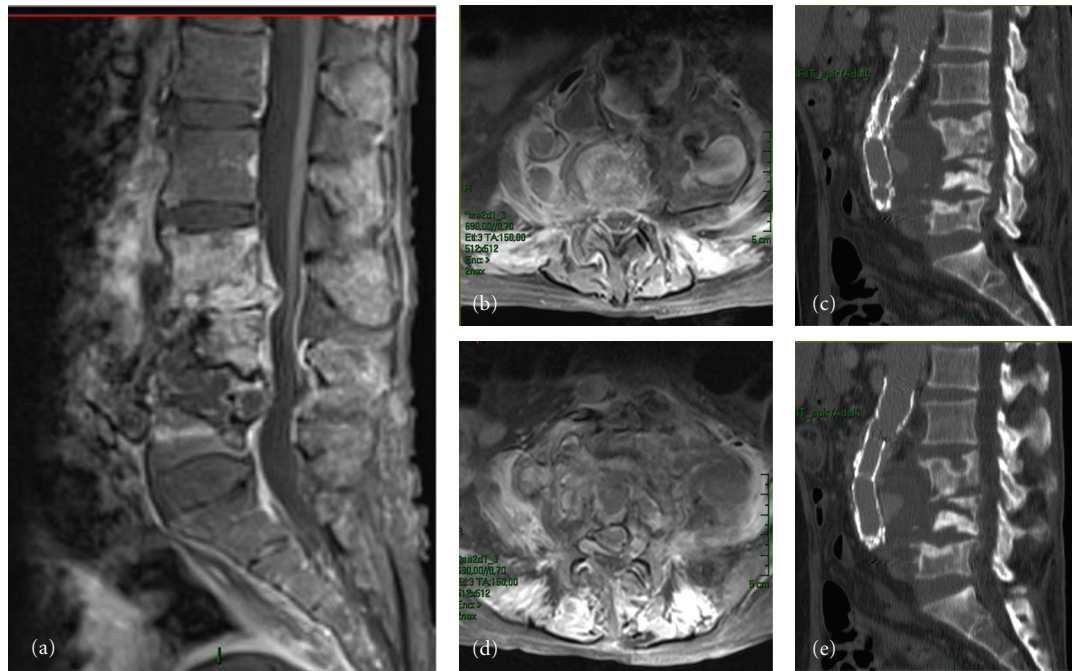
(a) Sagittal MRI, T1 showing the extension of the infectious process to three vertebral bodies L3-L4-L5 and to the intervertebral discs, as in a case of spondylodiscitis. ((b) and (d)) Axial MRI, T2 showing the paravertebral extension of the infection as well as an important compression of the sack and roots by the infection. ((c) and (d)) Sagittal CT showing the erosion and an extended rehaching of the bone as well as the involvement of the aortic prosthesis which has in part been pushed forwards by the infection. The CT also shows the integrity of the vertebral plain of the vertebrae adjacent to the damaged ones.
